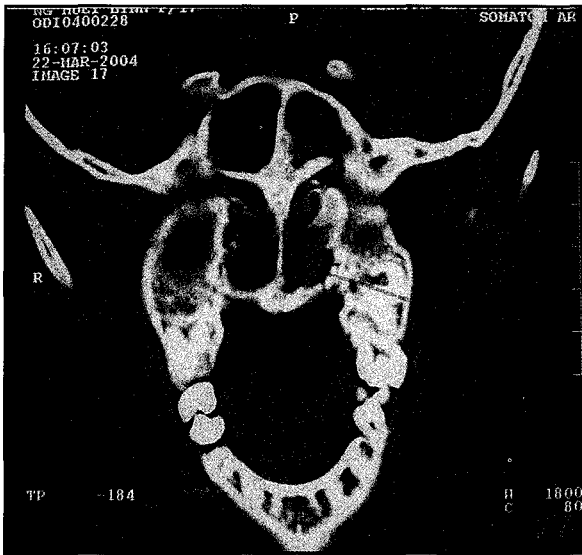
CT scan axial view shows complete stenosis of left posterior choana with soft tissue density mass.
